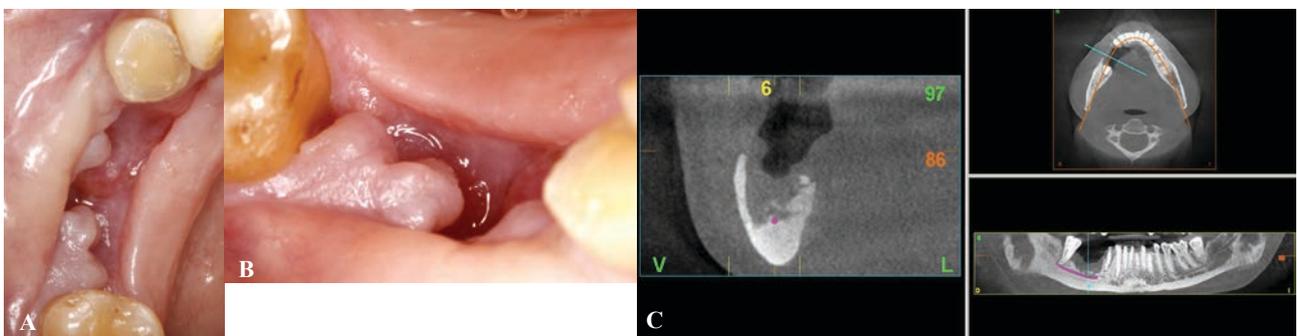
Appearance of the tissue after 4 weeks. The newly formed tissue at the bottom of the defect has matured and we can consider the closure of the surgical wound a success, as there is no bone exposed to the oral cavity. (C) CBCT images showing the complete excision of necrotic bone and the start of bone regeneration from the lingual cortical wall to the centre of the defect.
